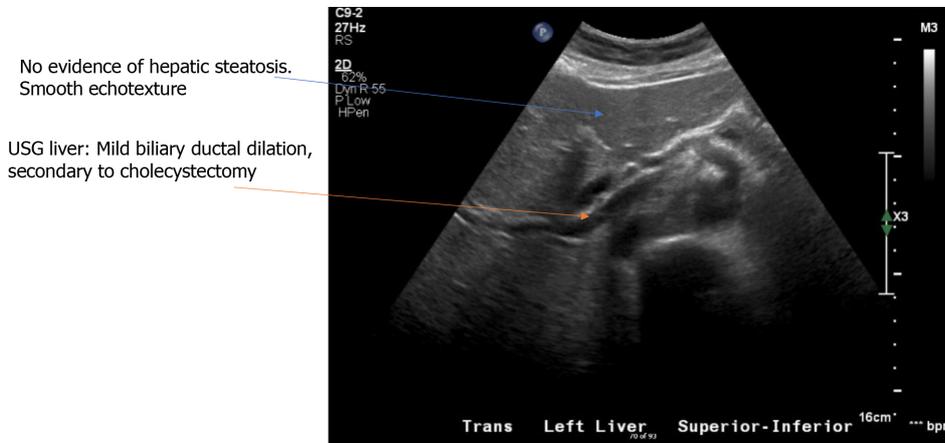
Ultrasonography liver.
